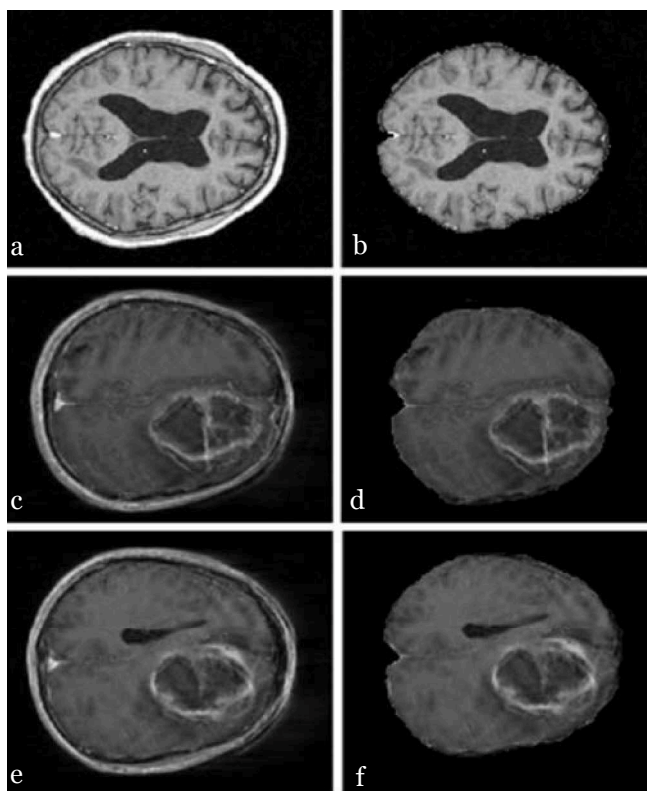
T1-weighted MR images before and after the skull stripping algorithm was applied. a) Sample MR image with a normal brain, c and d) two slices of brain MRI containing a GBM tumor. The resulting images after applying the skull-stripping algorithm are shown in b, d, and f. It can be observed that even in presence of severe intensity non-uniformity and noise in c and e, a robust stripping is obtained.
